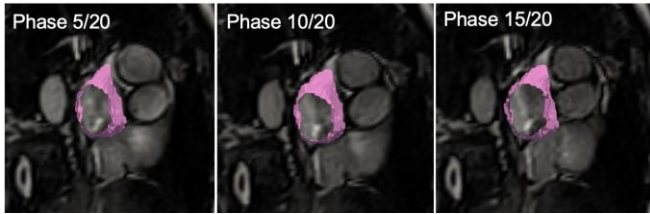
Left atrium mesh (in white) obtained upon image tracking overlaid on the acquired CINE MRI in three different phases of the cardiac cycle (indicated in each subfigure), for one imaged patient.
